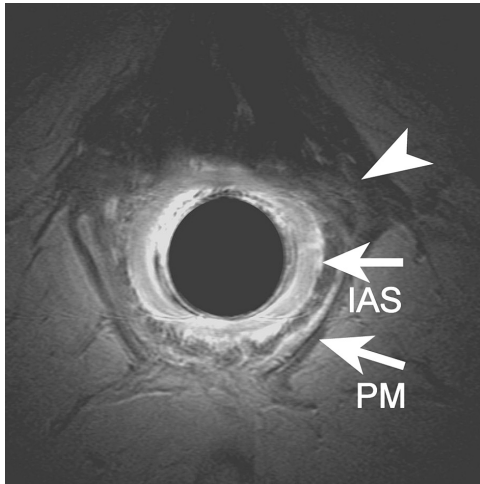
Transverse endoanal T2- weighted fast spin-echo (2500/70) MR image at the proximal anal canal in a 69-year-old woman with a complicated vaginal delivery and hysterectomy in the past. Anal sphincters were diagnosed as intact. Retrospectively, slight asymmetry of the structures (arrow head) left anterolateral to the internal anal sphincter as compared to the right anterolateral site can be seen; most likely representing the external anal sphincter defect diagnosed at surgery. IAS = internal anal sphincter, PM = lower edge puborectal muscle
